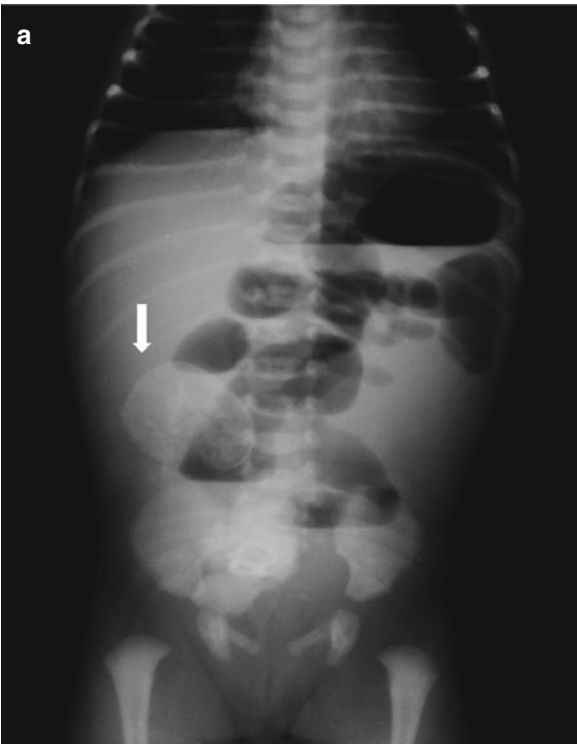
(a, b) Plain film in newborn with meconium ileus peritonitis shows the presence of distended loops. Note the calcific pseudocyst (*white arrow*). There are air-fluid levels due to the peritonitis
